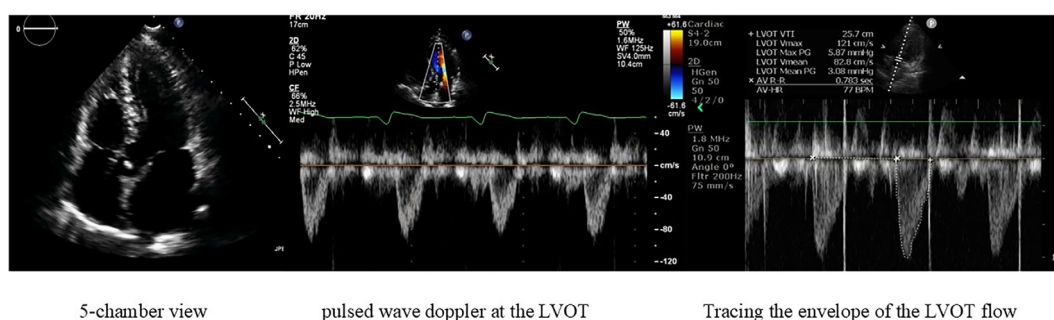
LVOT VTI obtained by tracing the envelope of the LVOT flow produced with pulsed wave doppler interrogation, obtained in an A5C view.
